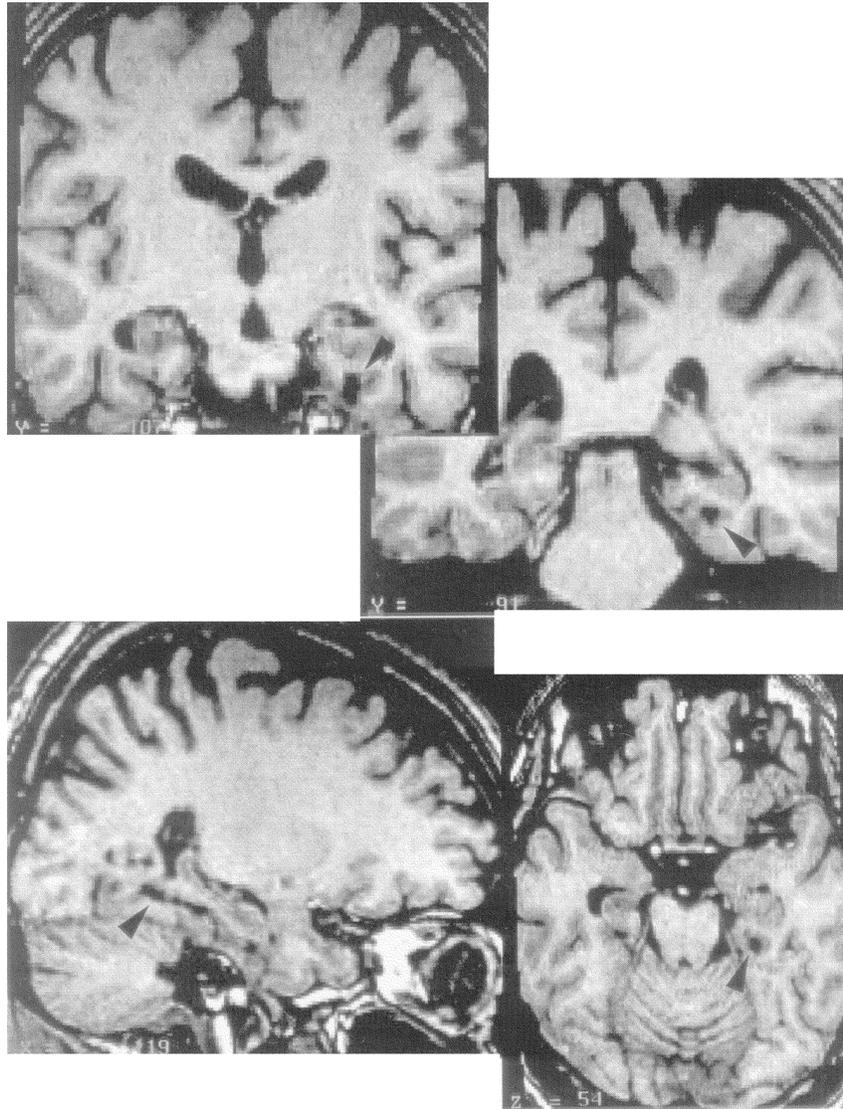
Thermal lesion to the right parahippocampal cortex. MRI sections in coronal, horizontal, and sagittal planes of a brain transformed into Talairach⁴² standard stereotaxic space. *Arrows* point to the lesion in the right parahippocampal cortex sparing the hippocampus.
